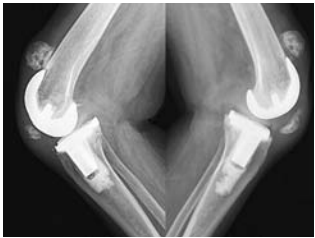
Preoperative radiographs demonstrate chronic disruption of the extensor mechanism of both knees with an avulsion of the inferior pole and proximal migration of the patellae.
